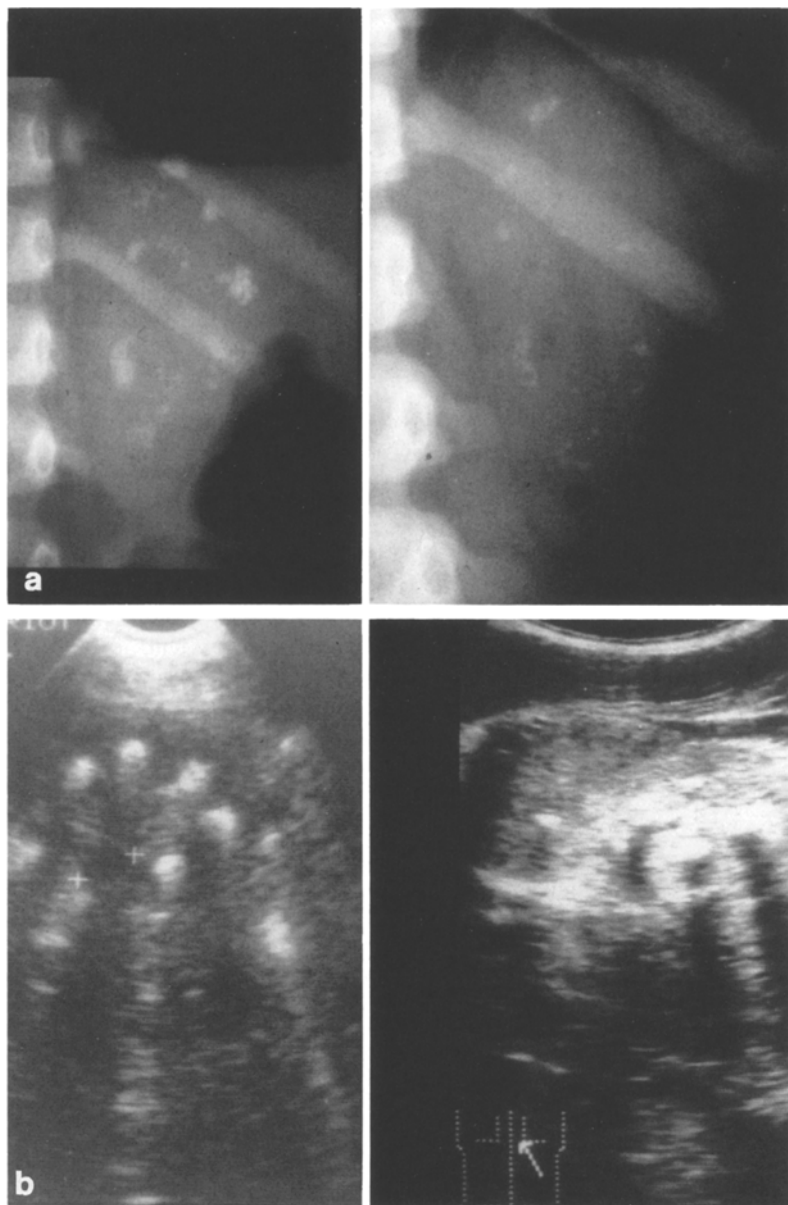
a. Standard X-ray of the left native kidney before (*left*) and 3 years after (*right*) liver transplantation. b Ultrasonography of the native kidney before (*left*) and 3 years after (*right*) liver transplantation
